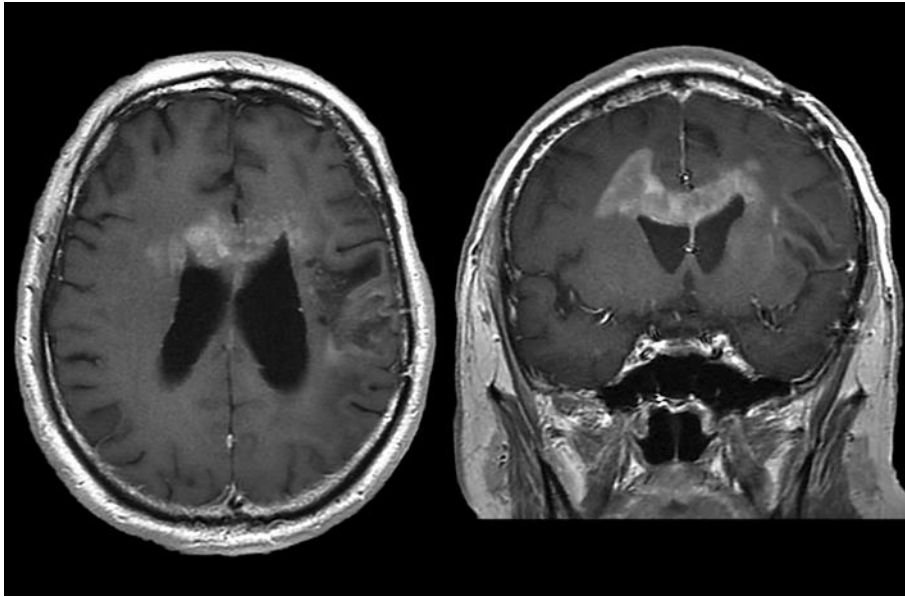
Serial magnetic resonance (MR) and  $^{11}\text{C}$ -methionine positron emission tomography (MET-PET) images. a Primary images of the tumor. Axial and coronal Gd-enhanced T1-weighted MRI shows a left frontal lobe tumor with ring enhancement. A strong perifocal edema can be seen on the T2-weighted image. High MET uptake on PET corresponds to the enhanced lesion. The ratio of the standardized uptake value to the contralateral normal tissue (T/N ratio) was 3.1. b Gd-enhanced T1-weighted MRI and MET-PET reveal tumor recurrence (T/N ratio: 2.8), and T2-weighted MRI shows deterioration of the edema after radiotherapy plus concomitant and adjuvant temozolomide therapy. c Complete remission, as assessed by the Response Assessment in Neuro-Oncology (RANO) criteria, demonstrated after administration of bevacizumab (BEV) for 2 months, and MET uptake almost disappeared after initiation of BEV (T/N ratio: 1.8). d T1-weighted MR, Gd-enhanced T1-weighted MR, MET-PET, and MET-PET/MR fusion images 17 months after initiation of BEV. No enhanced lesion can be seen on Gd-enhanced MRI, but MET-PET detected non-enhanced tumor recurrence (T/N ratio: 2.5).
